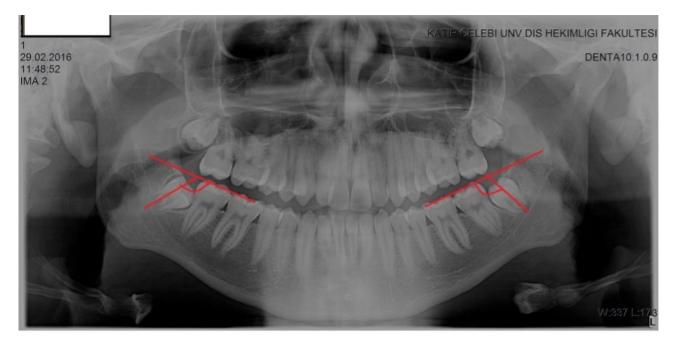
Orthopantomogram image of a patient with bilateral, symmetrically impacted third molars in the lower jaw
